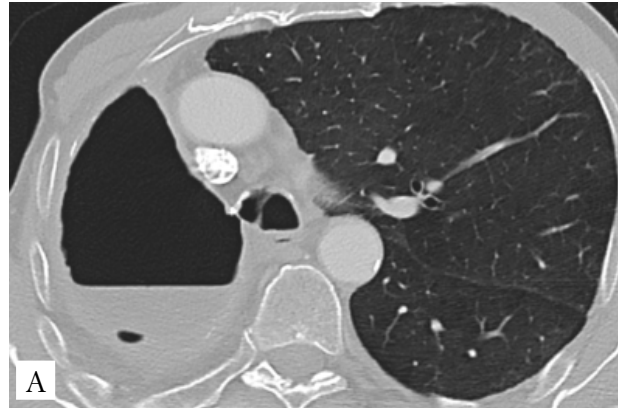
Pre-interventional CT scan demonstrating a predominantly air-filled right post-pneumonectomy cavity with visible lateral bronchial stump insufficiency (A). Follow-up CT scan six weeks after Amplatzer occluder implantation demonstrating stable positioning at the broncho-pleural fistula with pleural drainage still in situ (B) (Case 3)
